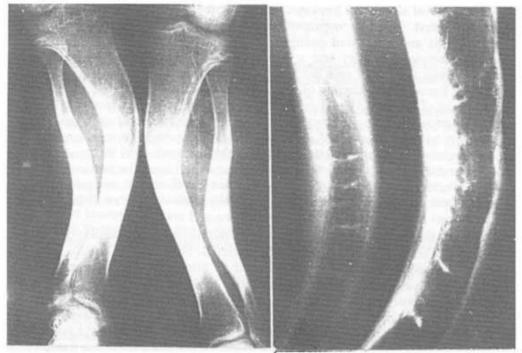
(left) Frontal radiographs of left and right lower legs showing malformed (curved) tibia and fibula FIGURE 2 (right) Magnified frontal radiograph of tibia and fibula, showing widened ground-glass-like cortex and disordered ossification of trabeculae
